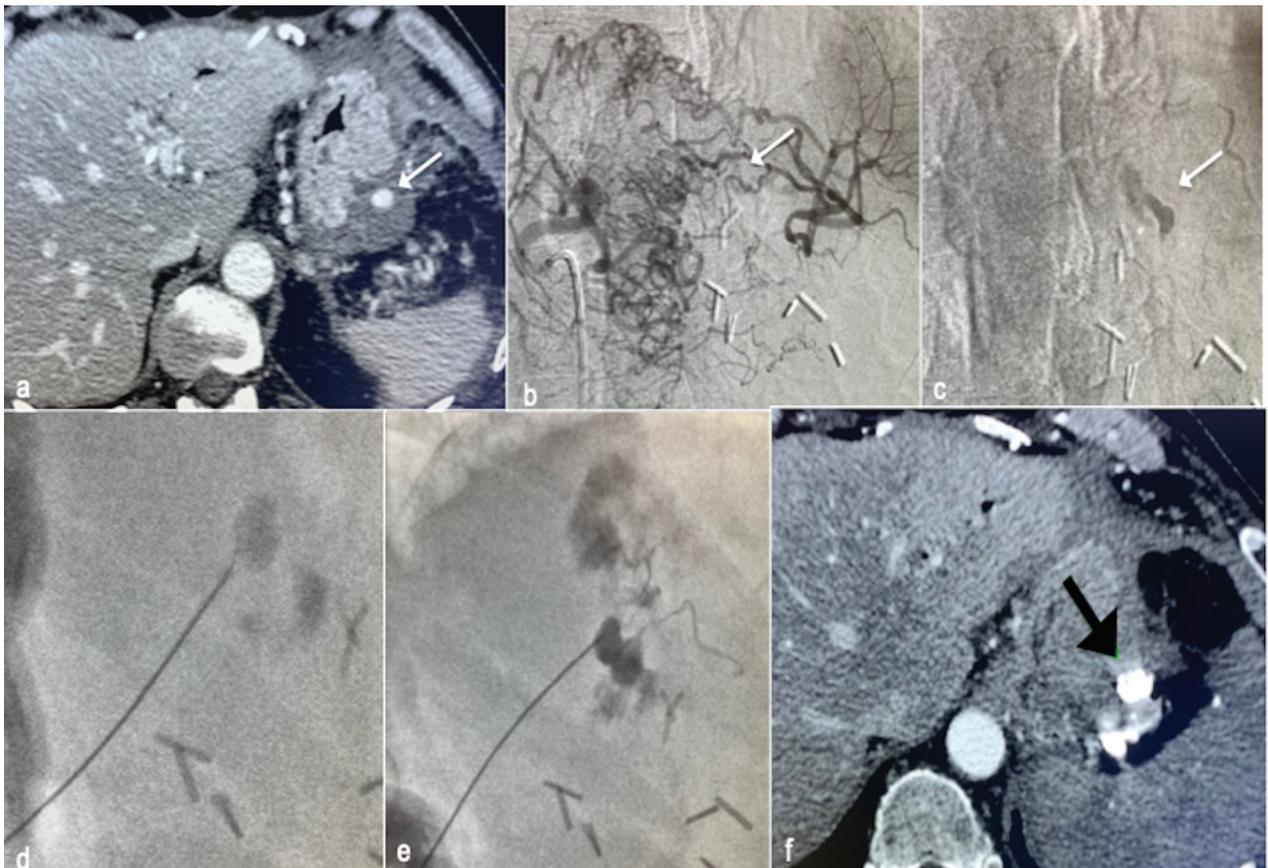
CT scan reveals gastric pseudoaneurysm (PSA) (a); arteriogram of the celiac trunk shows occlusion of the splenic artery and the PSA filled by small vessels, impossible to catheterize (b); contrast medium remained in the PSA (white arrow,c); percutaneous puncture was performed under fluoroscopic guidance (d); glue was used as embolic agent (e); CT was performed to check the complete embolization of the PSA (black arrow, f).
